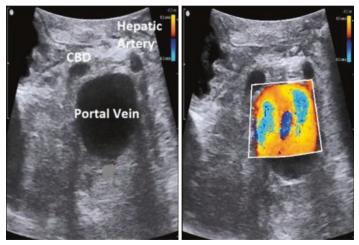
Laparoscopic ultrasound probe resting on porta hepatis and images obtained. Lateral to medial USS wave direction; USS autorotation to AP view
